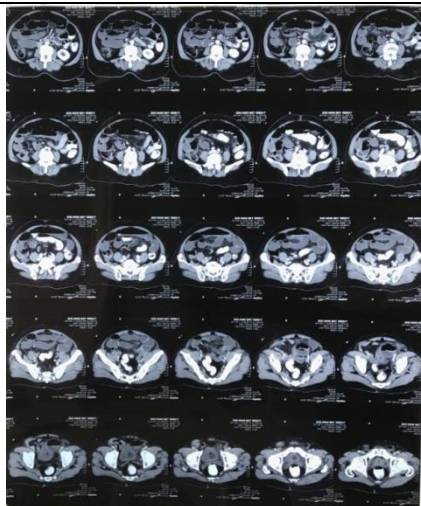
CT Abdomen showing small bowel close loop obstruction.
